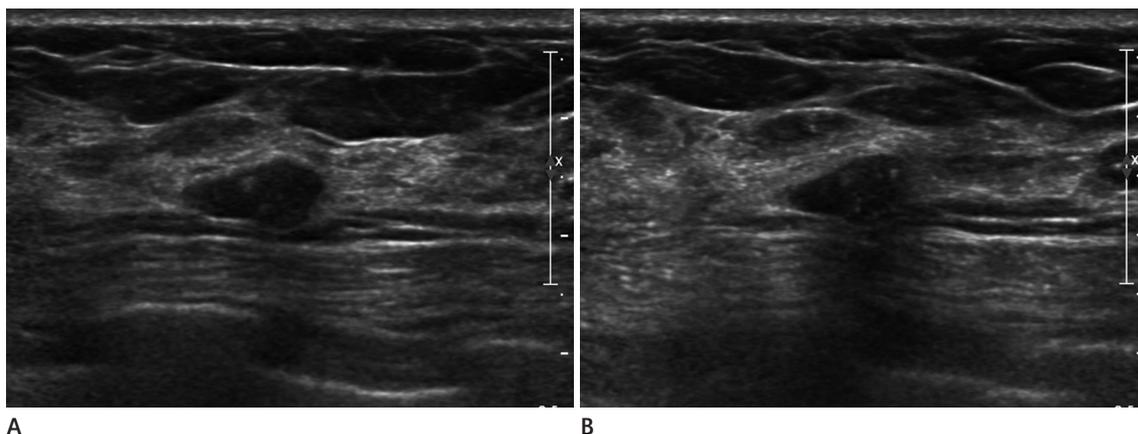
Ultrasound findings. Ultrasound (A: transverse view, B: longitudinal view) shows a circumscribed ovoid mass with internal echogenic dots in the right breast, 6 cm from the nipple.
